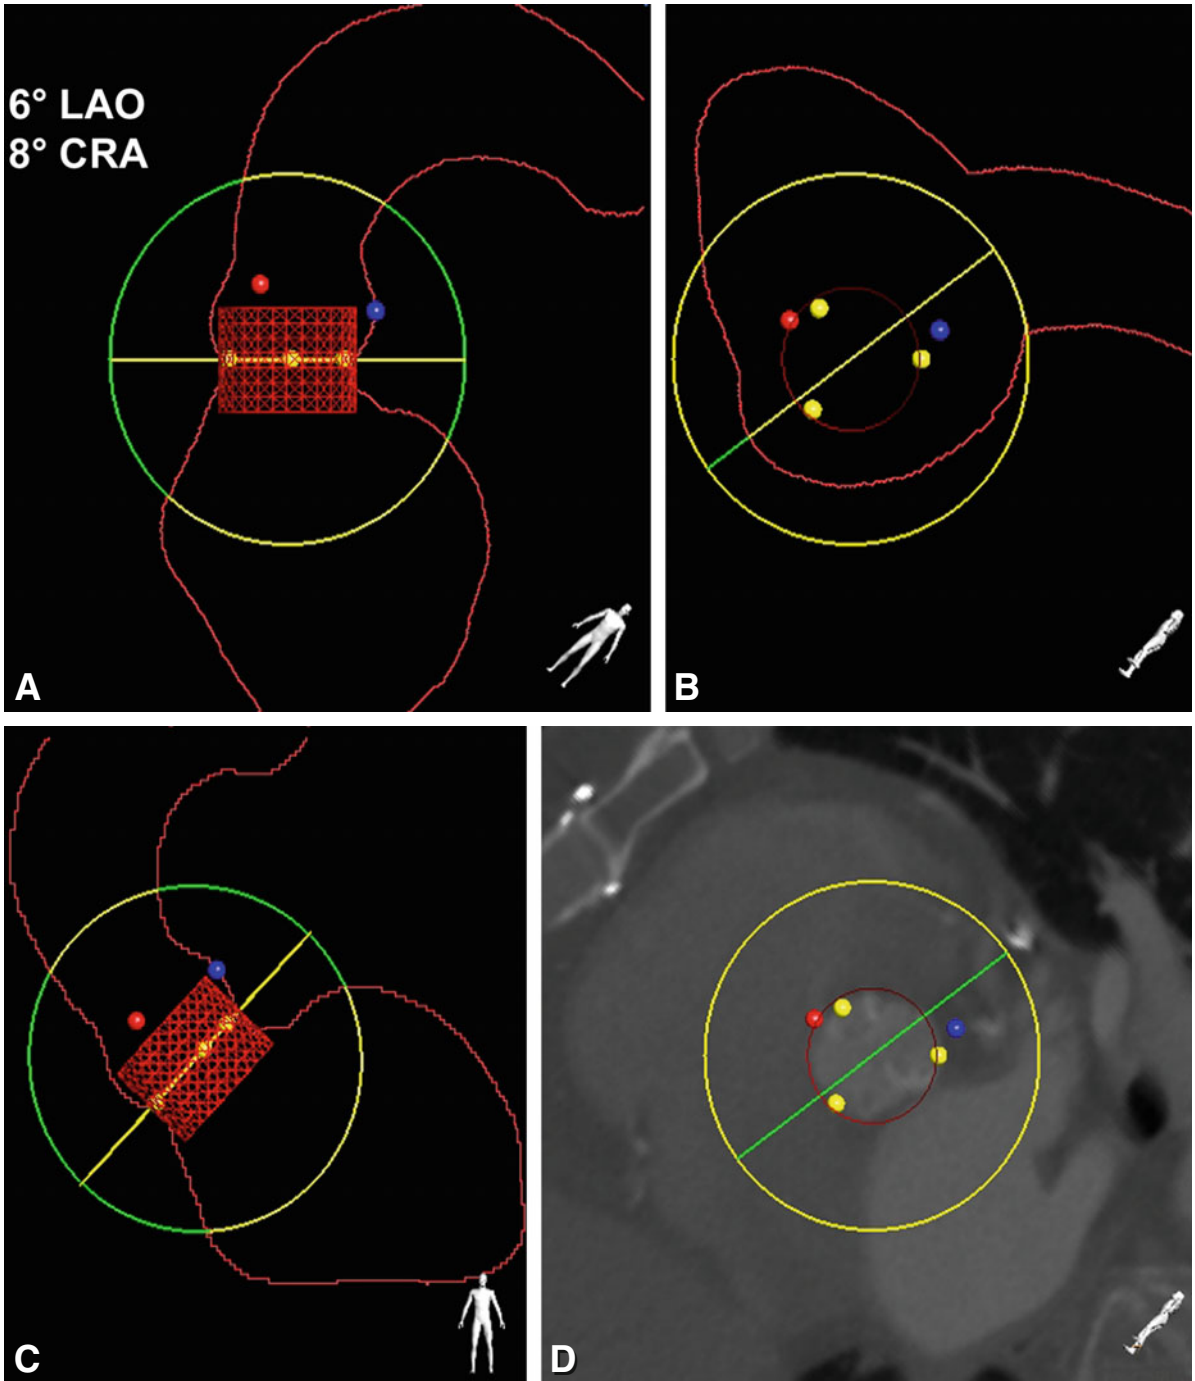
Image fusion to predict the optimal angle for valve deployment and to assess the aortic annulus for device sizing. The CT datasets with the ascending aorta and the left ventricle have been matched to display the aortic arch in 'outline rendering' (Panel A). The red and blue landmarks represent the coronary ostia, while the three yellow landmarks indicate the three aortic valve cusps. The yellow circle outlines the 'plane of the valve', while the green circle is perpendicular to this plane (Panels B and C). The red mesh is a 'virtual device', which is chosen from a library of approved valves and reflects the true dimensions of the expanded aortic valve (Panel C). The 'optimal X-ray view' in this particular case was 6°LAO and 8°CRA. The plane of the aortic valve (Panel B) can also be viewed on actual CT data (Panel D) to see how the virtual devices will fit into the patient's individual anatomy
